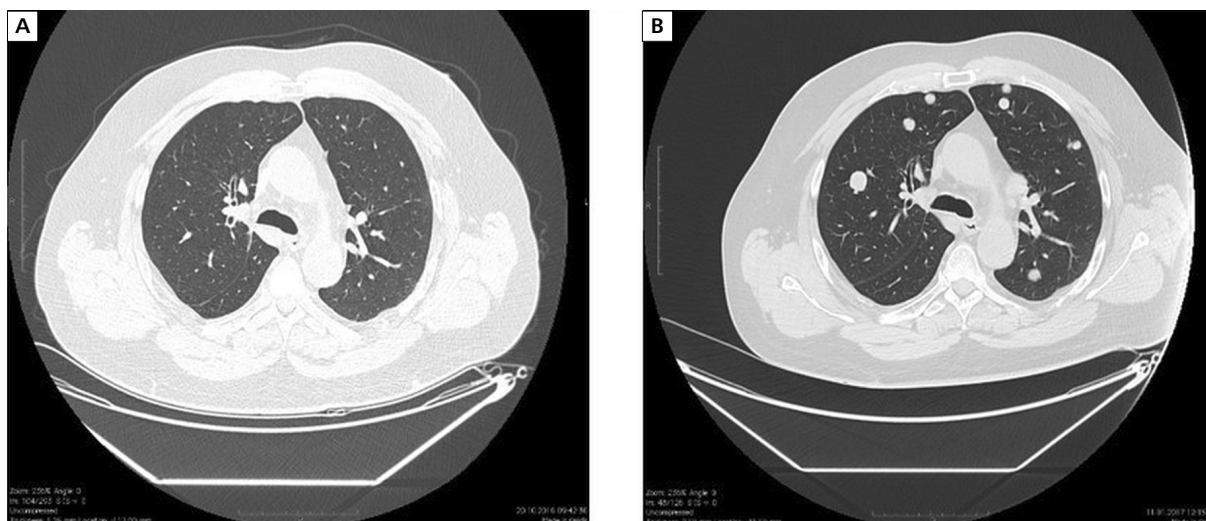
Monitoring of the response to immunotherapy (nivolumab). A) CT scan performed at the moment of patient qualification to the immunotherapy (November 2016); B) CT scan showing rapid progression of the disease with numerous disseminated tumors during immunotherapy (January 2017)
